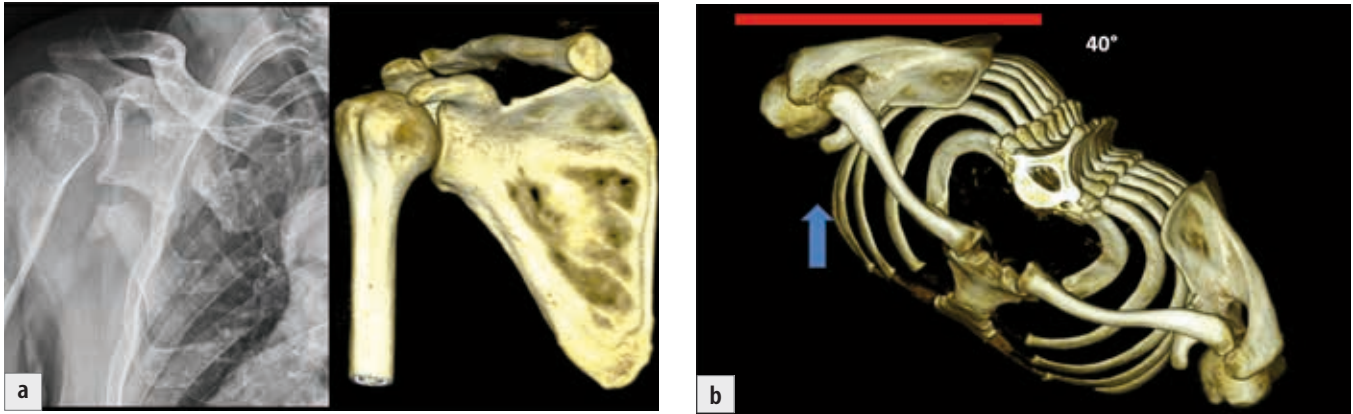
Anteroposterior view of the scapula (Neer I projection): a) radiograph and CT reconstruction; b) position of the scapula and the X-ray cassette.
